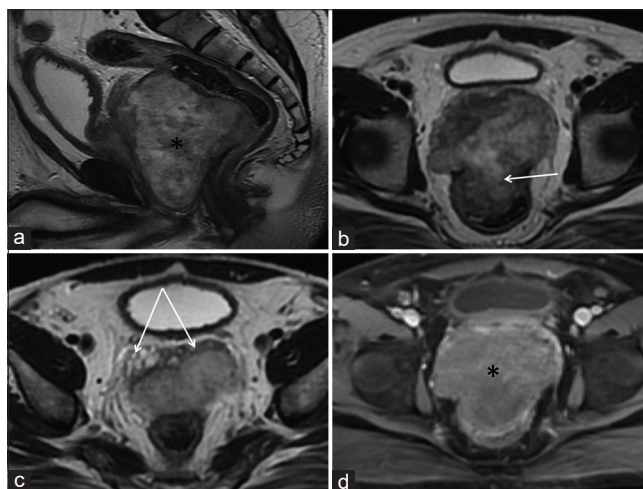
Magnetic resonance imaging of the pelvis showing a large heterogeneously hyperintense mass (* in a and d) with heterogeneous enhancement replacing the entire prostate gland. It invades the rectum posteriorly (arrow in b) and the seminal vesicles (arrows in c). Note that the bulk of the tumor is in the prostate
